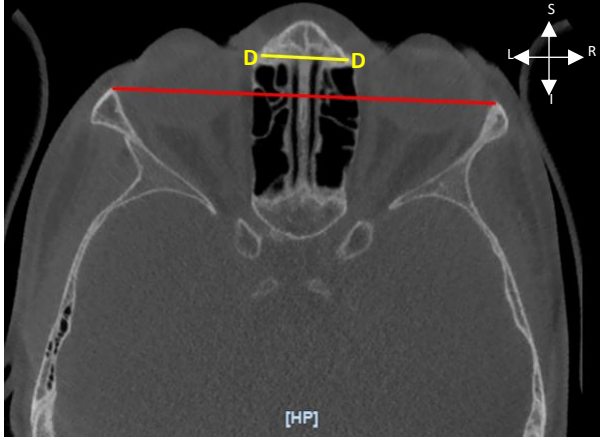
Horizontal CT scan in the orbital region displaying the AID (Yellow) and LOD (Red) (Superior view)
